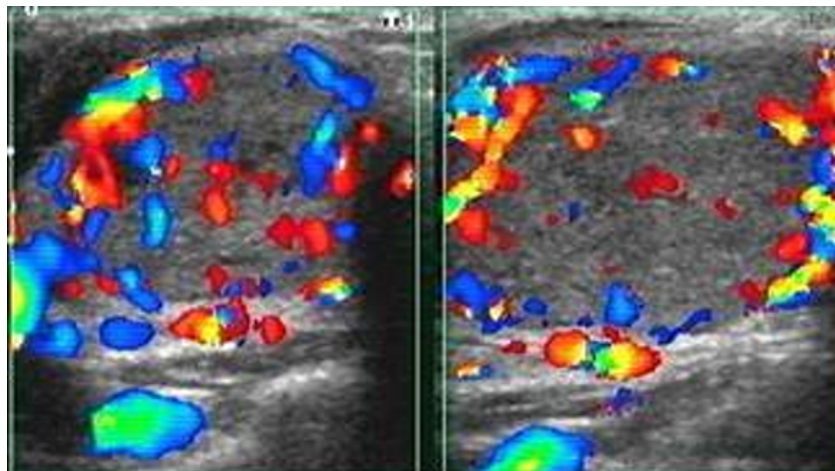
Color Doppler of thyroid nodules showing intranodular vascularity.
